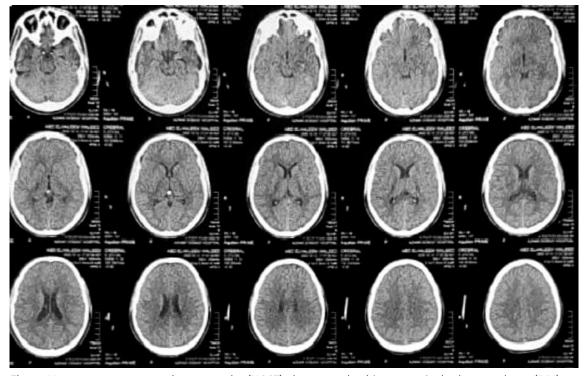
Non-contrast computed tomography (NCCT) shows resolved intraventricular haemorrhage (IVH) on the 4^{th} day of admission.
